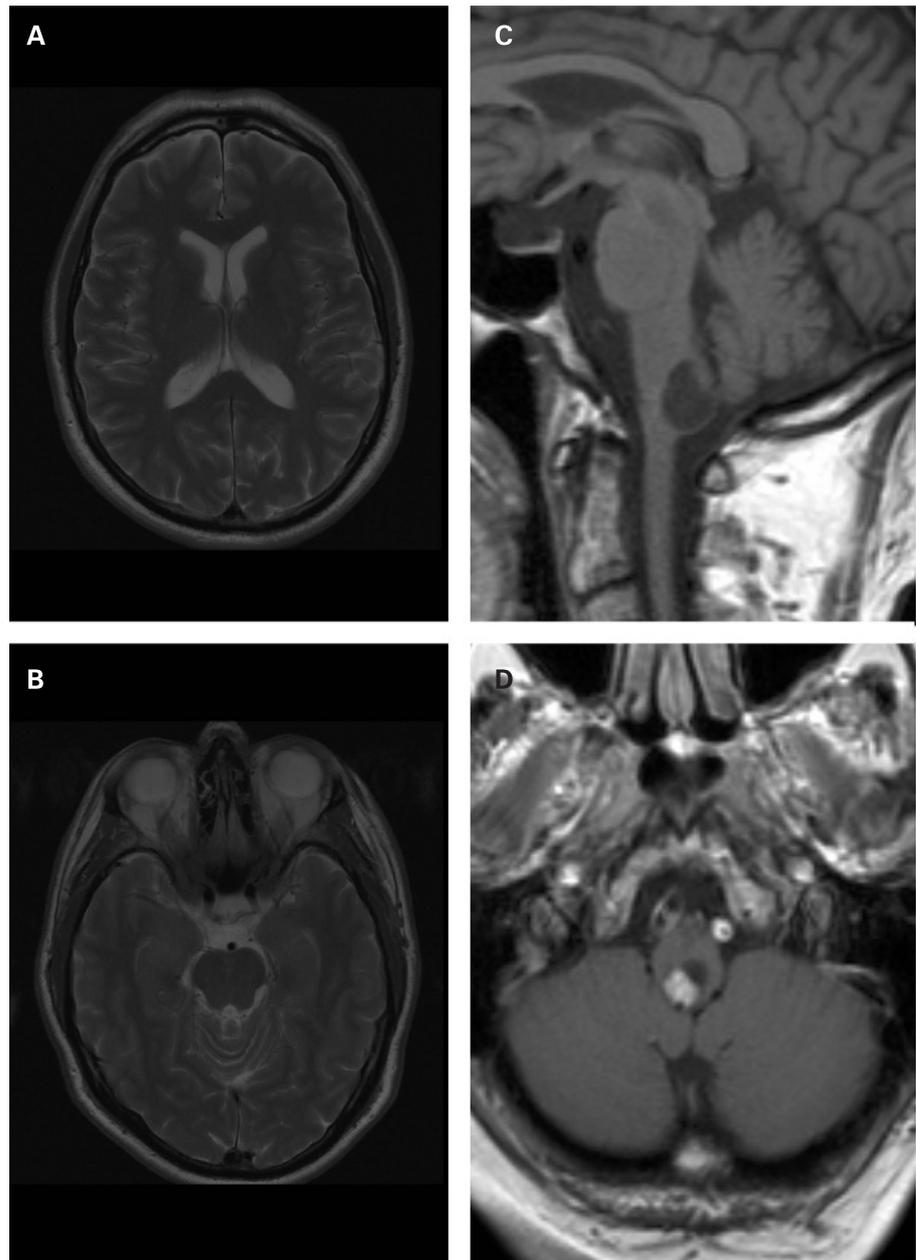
Magnetic resonance imaging. Axial T2-weighted fast-spin echo images (A, B) show no hydrocephalus or temporal lobe lesions. Sagittal T1-weighted spin echo (C) and post-gadolinium axial T1-weighted spin echo (D) images show a cystic lesion in the dorsal medulla oblongata with an enhancing mural nodule.
